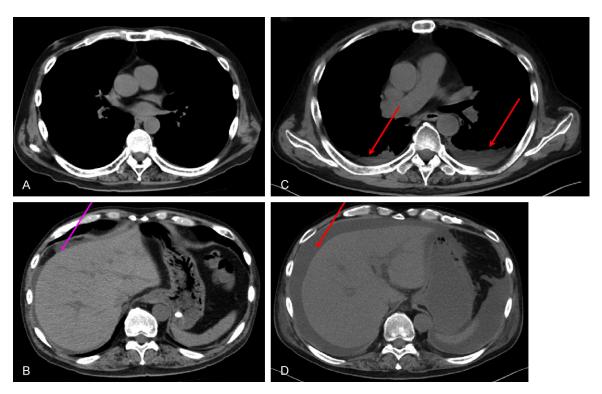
CT. A. (day 6): No pleural effusion. B. (day 6): Modest ascites. C. (day 12): Bilateral pleural effusion. D. (day 12): Worsening of the ascites. MCVAC therapy, ranimustine, cytarabine, etoposide, cyclophosphamide; rTM, thrombomodulin α ; SNMC, glycyrrlizin-containing preparation; UDCA, ursodeoxycholic acid; PE, plasmaexchange; PSL, Prednisolone; mPSL, methylprednisolone; CT, computed Tomography; AST, aspartate aminotransferase; ALT, alanine aminotransferase; AT3, antithrombin 3; Fer, ferritin; Y-Bil, total bilirubin.
